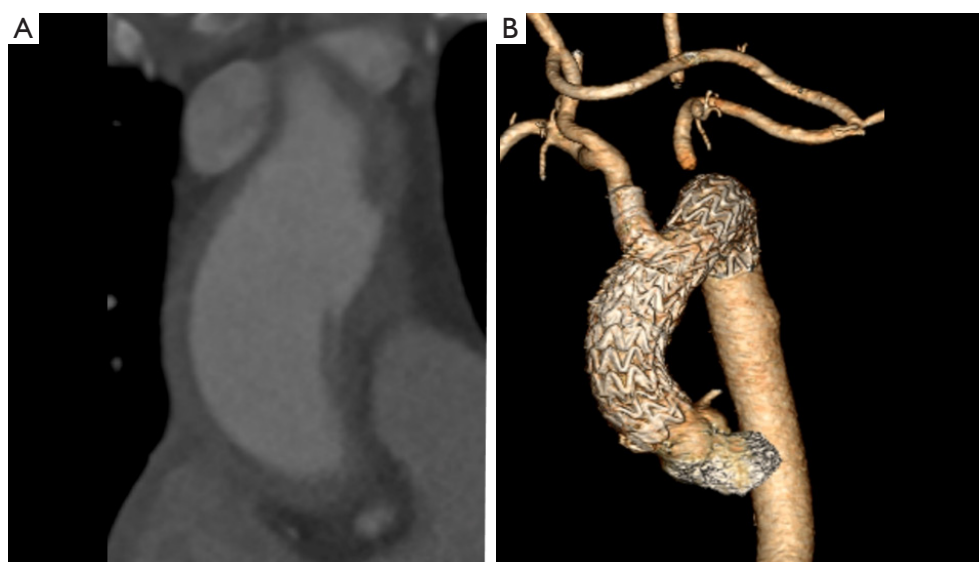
Pre- and post-operative 3D CTA-reconstruction of a patient with local acute type A aortic dissection (A) managed with cervical debranching (carotid-carotid-subclavian bypass) followed by implantation of a GORE TBE in zone 0, completed with a GORE CTAG to the sinotubular junction (B). 3D, three-dimensional; CTA, computed tomography angiography.
